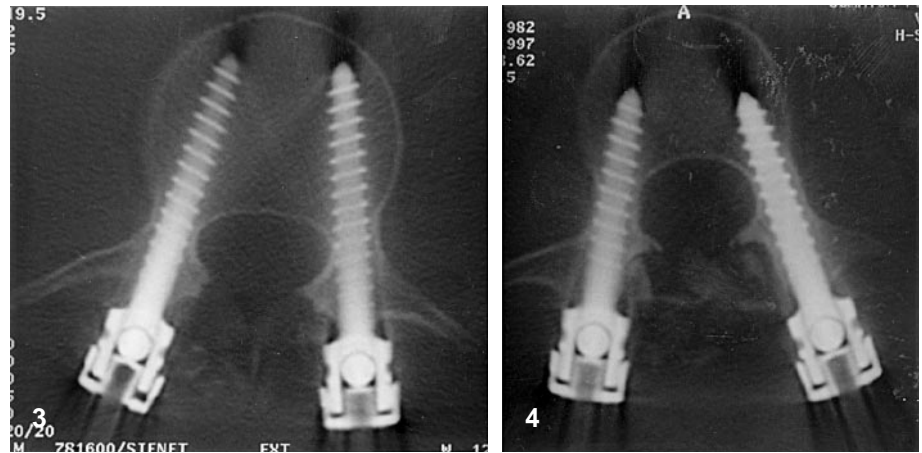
Computed tomographic (CT) scan of L3 with both pedicle screws strictly intra-pedicular
